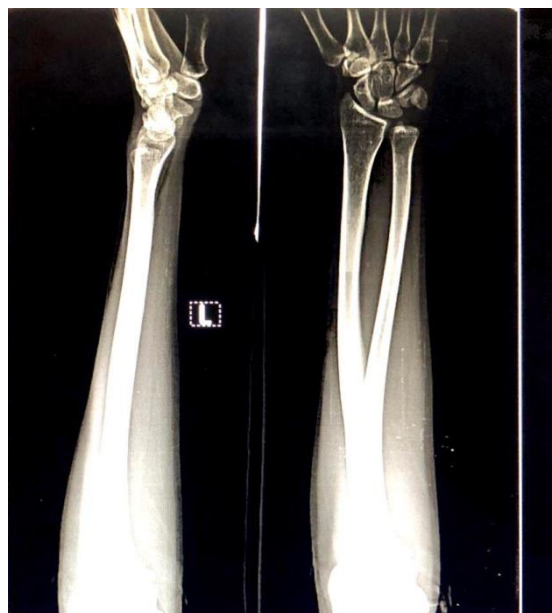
X-ray showing calcification
